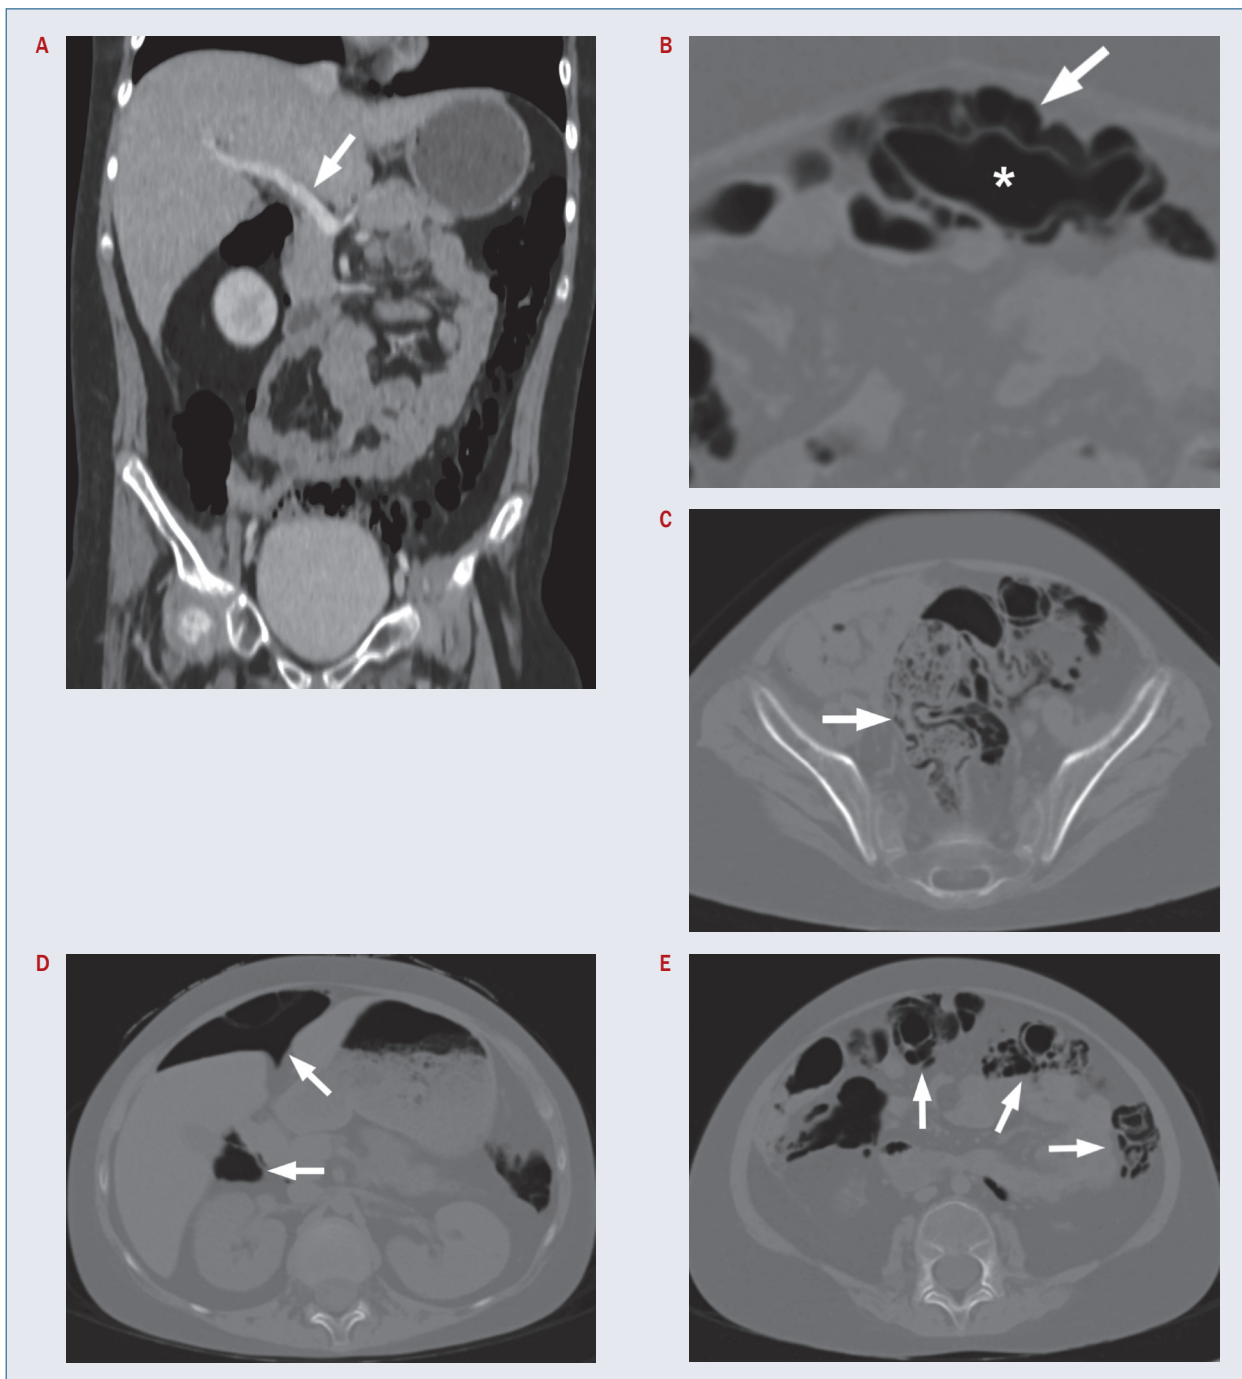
Pneumatosis intestinalis in computed tomography imaging: A. Contrast-enhanced computed tomography (CT). No evidence of gas in portal vein (arrow); B. Non-contrast-enhanced CT. Zoomed image of transverse colon. Gas in lumen of intestine (asterisk) and gas in expanded intestinal wall (arrow); C. Non-contrast-enhanced CT. Pneumatosis of sigmoid colon (arrow); D. Non-contrast-enhanced CT. Gas in peritoneal cavity (arrows); E. Non-contrast-enhanced CT. Pneumatosis of transverse colon and descending colon (arrows)
